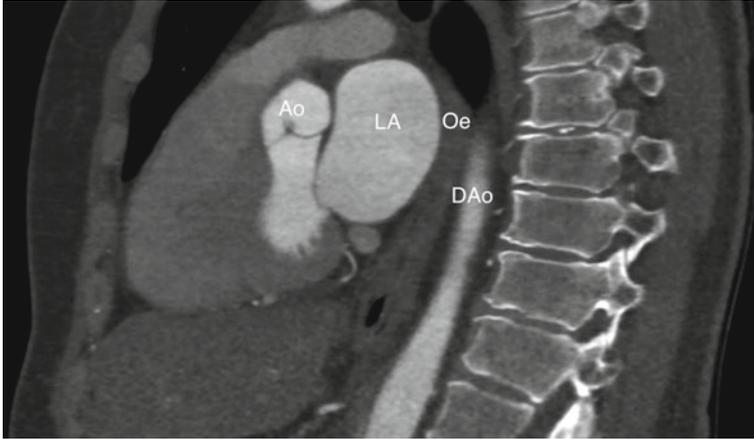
CT showing proximity of esophagus to the posterior wall of the left atrium. In this lateral image the ascending aorta (*Ao*) is anterior to the left atrium (*LA*). The oesophagus (*Oe*) is posterior to the left atrial wall. Also seen in this image is the descending aorta (*DAo*)
